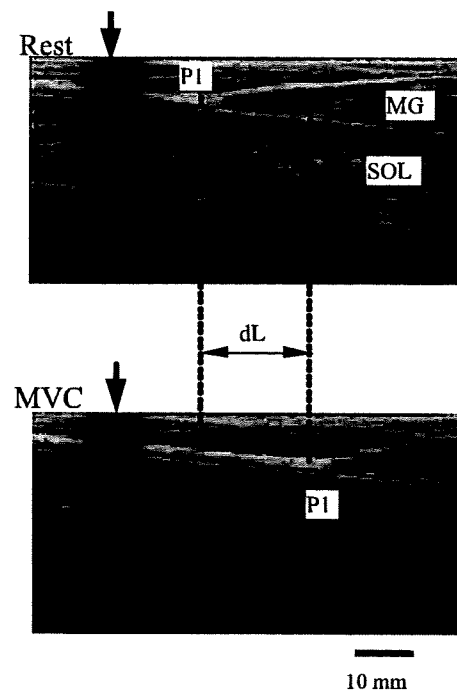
Ultrasonic images of longitudinal sections of the Achilles tendon at rest and MVC. The black arrows point to the shadow generated by an echo-absorptive marker attached by adhesive to the skin. P1 and P2 moved proximally during isometric torque development from rest to MVC. The distance traveled by P1 and P2 (dL) was defined as the elongation of the Achilles tendon during contraction.
